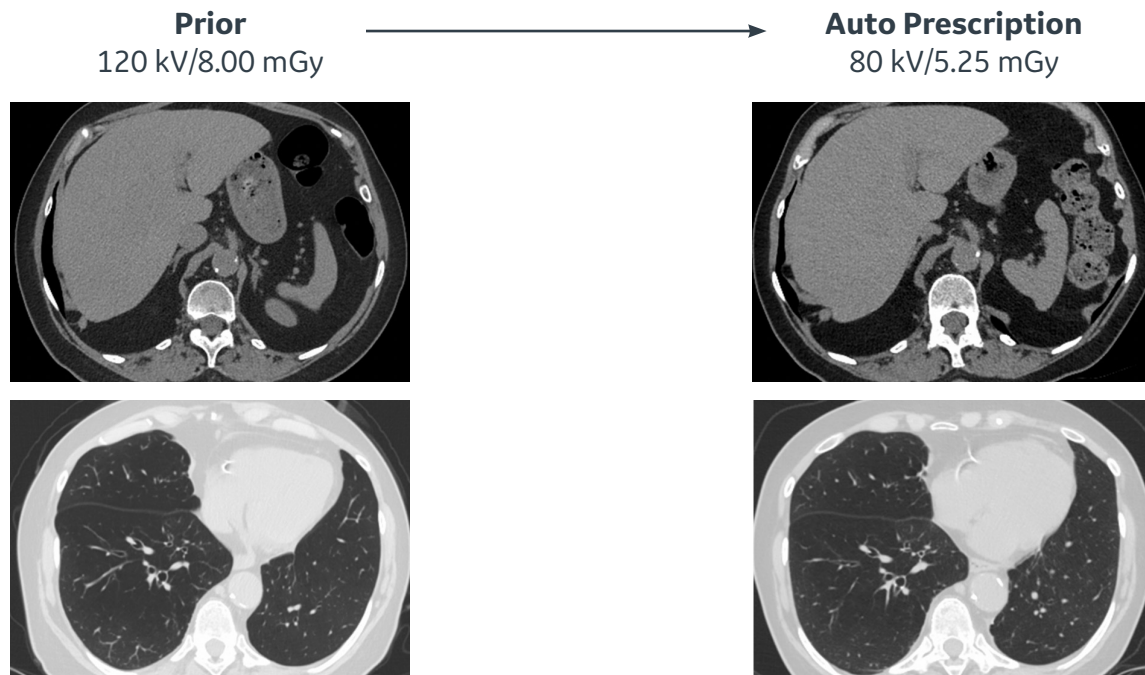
Same patient scanned on Revolution CT at 120 kV/8 mGy without Auto Prescription and at 80 kV/5.25 mGy with Auto Prescription (GE Thorax Profile). Both images were reviewed by a radiologist and rated above acceptable image quality. Reconstructions were performed using DLIR-M (top) and ASiR-V 0 (bottom).
